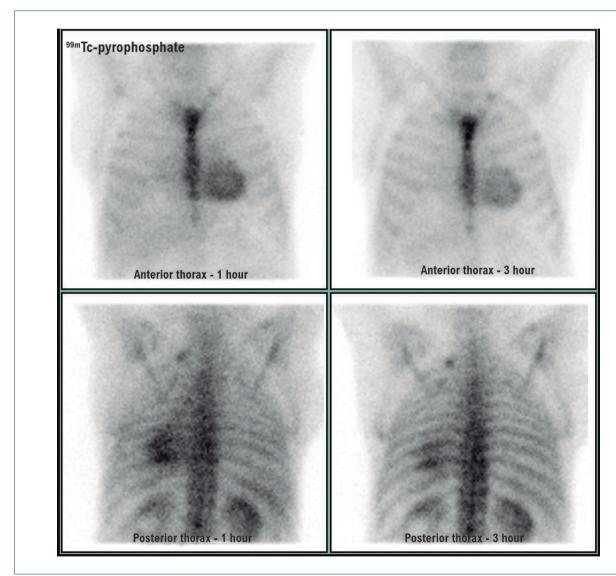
Technetium pyrophosphate bone scintigraphy showing Perugini grade III uptake, 1 and 3 hours
